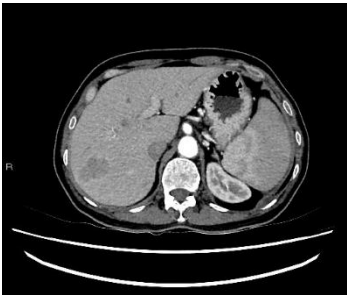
Arterial phase computed tomography scan of the liver. Lesion in segment VII remained hypodense when compared to surrounding liver parenchyma.
